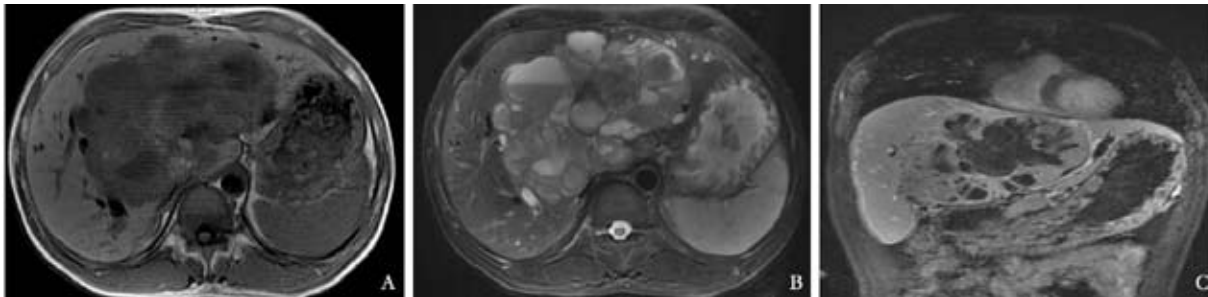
MRI scan images of a PHNEC patient. A: T1-weighted MRI showing a large low density liver mass with a lower density cystic area in the middle lobe; B: T2-weighted MRI showing a high density liver mass, especially in the cystic area with a fluid level; C: Coronal view image showing a large cystic-solid mass in the middle lobe.
